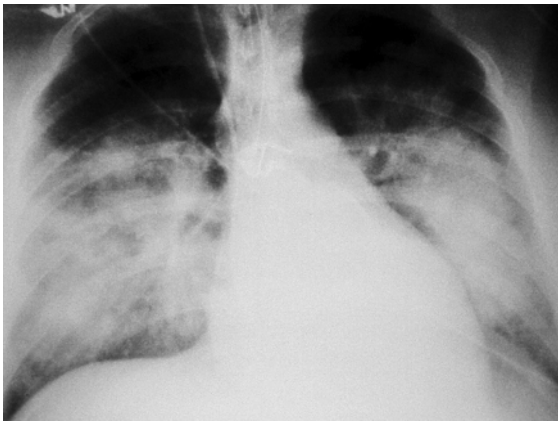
6a Chest radiograph of a patient with hantavirus pulmonary syndrome. Source: CDC/ D. Loren Ketai, MD; PHIL, 6076, 1994.
